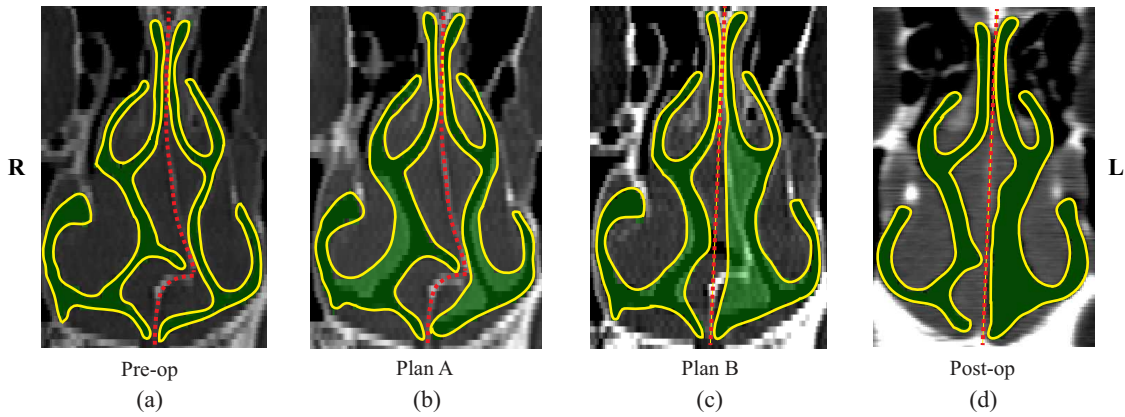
The coronal cross-sectional CT images of DNS patient #2 present the segmented nasal airways of the pre-operative nose (a), pre-surgical planning A (b), pre-surgical planning B (c), and post-operative nose (d). Dashed lines represent shapes of the septal cartilages. R and L are the right and left sides of noses.
